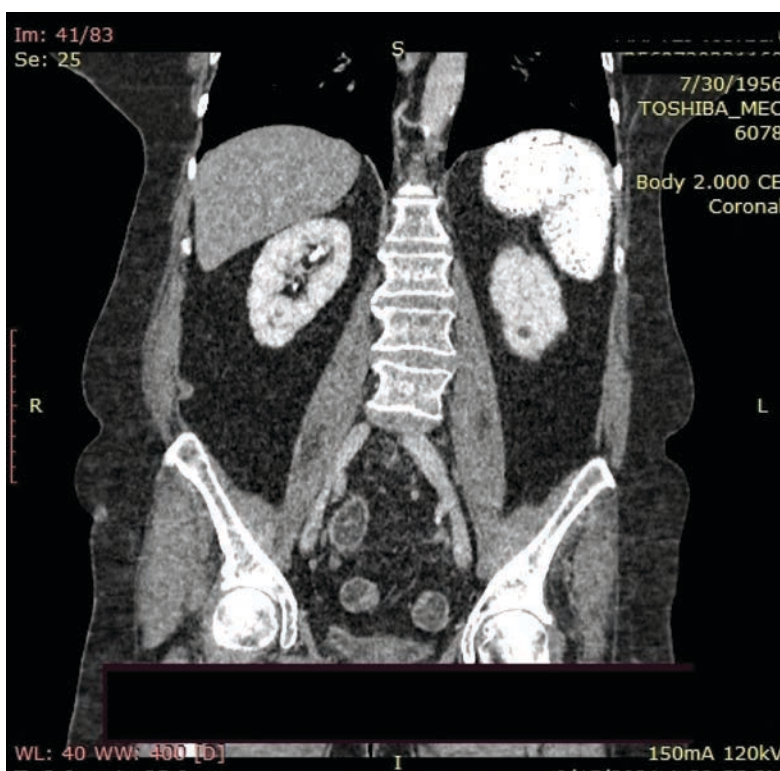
CT image - normal spleen size with completely calcified parenchyma
